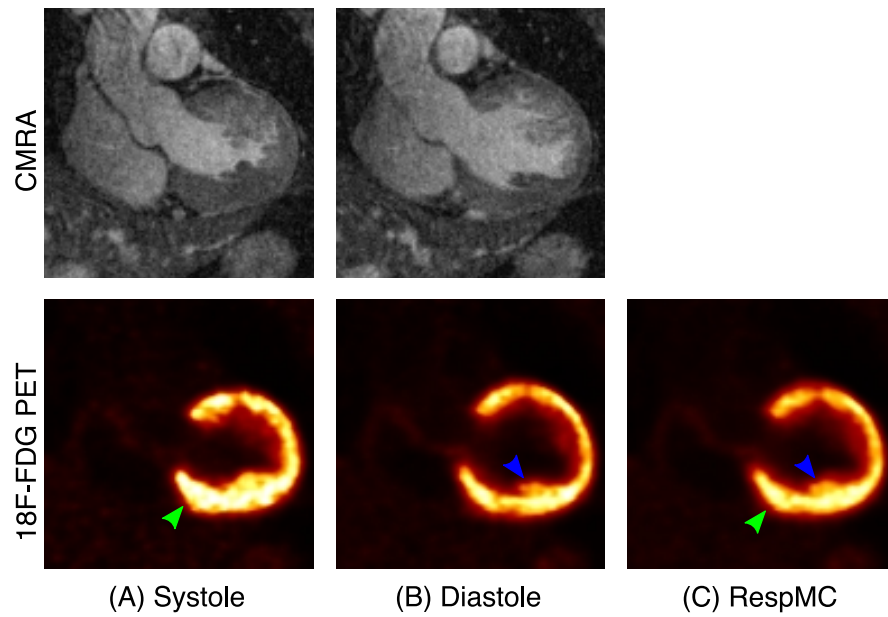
Coronal views from a cardiac patient, showing respiratory motion-corrected (a) systolic and (b) diastolic CMRA and ^{18}F -FDG PET images, alongside (c) respiratory motion-corrected (RespMC) PET image. RespMC aggregates data acquired at different cardiac phases, resulting in cardiac-induced blurring of small structures (blue arrow) and apparent thickening of the myocardium (green arrow).
